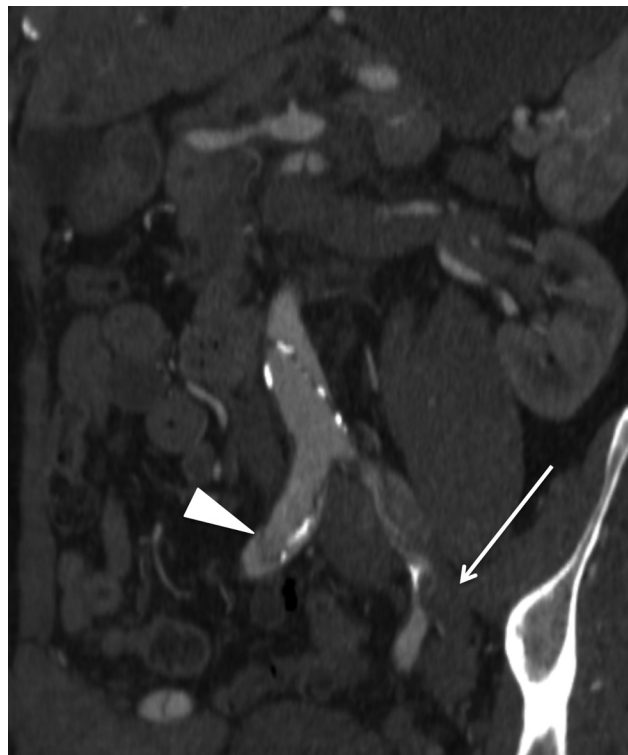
Preoperative computed tomography scan of the aortic bifurcation with intravenous contrast, reformatted image, highlighting occlusion of left external iliac artery with false lumen thrombosis (white arrow). Note patent but dissected right common iliac artery (white arrowhead).
